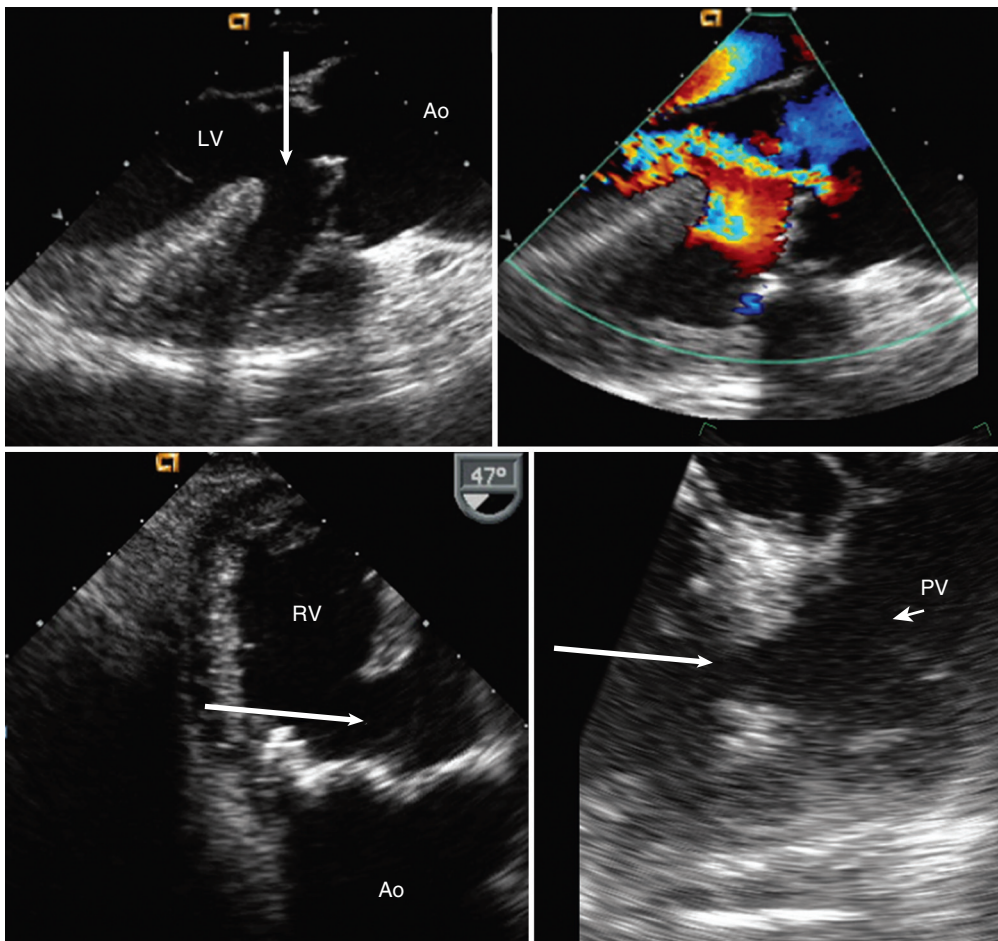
Transesophageal images of a patient with tetralogy of Fallot. Upper left, Midesophageal image showing the aorta (Ao) overriding a large (nonrestrictive) VSD (*arrow*). Upper right, There is mild aortic regurgitation. Lower left, From a deep transgastric view, severe right ventricular hypertrophy is seen. The *arrow* points to the VSD. Lower right, In this midesophageal view, focal infundibular narrowing is seen (*arrow*). The pulmonic valve (PV) is not well seen but, in other views, was shown to be normal. LV = left ventricle; RV = right ventricle.
